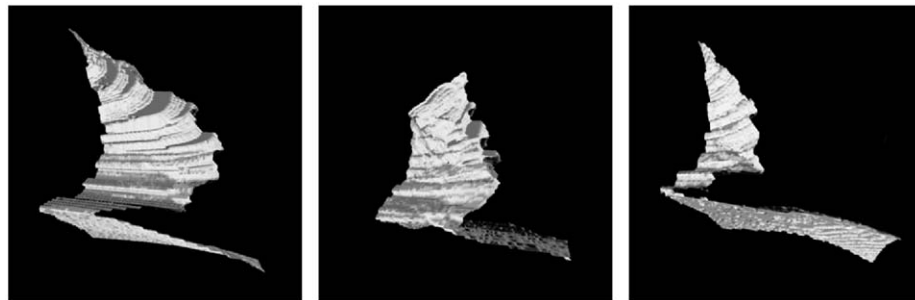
Appearance of the mediastinal pleura in a CT scan: the flatness of the diaphragmatic pleura can be compared with the knurled surface representing the mediastinal pleura.
